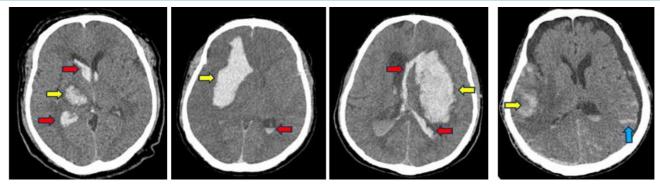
CT brain of different, known hypertensive patients shows, haemorrhages involving all regions of brain (yellow arrows), with intraventricular extension (red arrows) and few causing subarachnoid haemorrhage (blue arrows).
